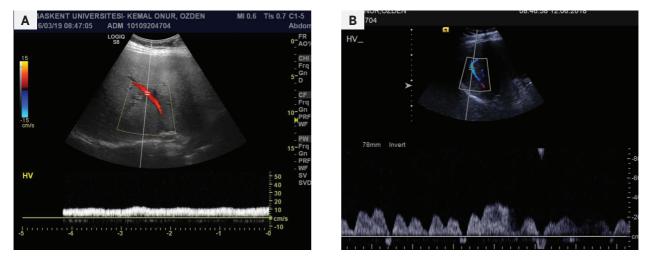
Doppler Ultrasonography Images of Transplanted Liver
